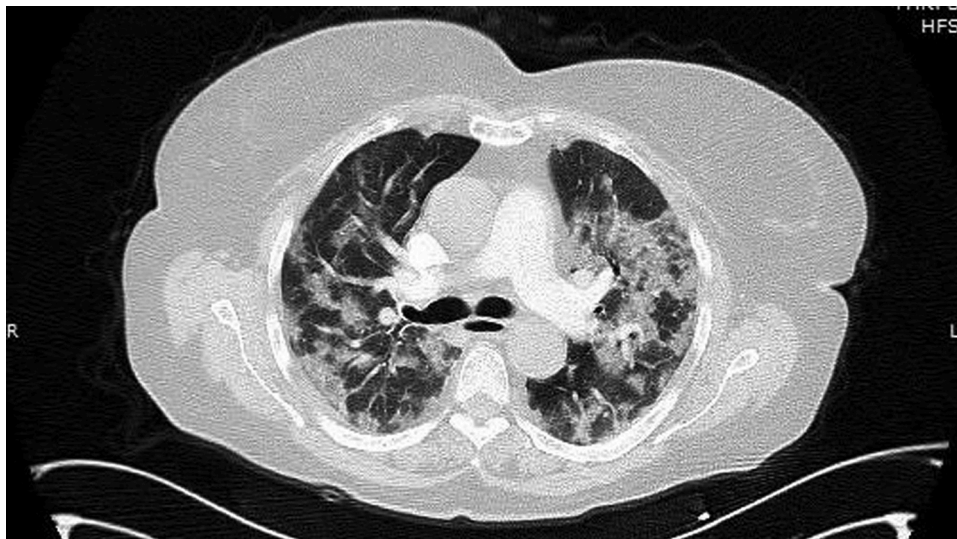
Thorax CT showing bilateral multiple consolidations on 14th day.
